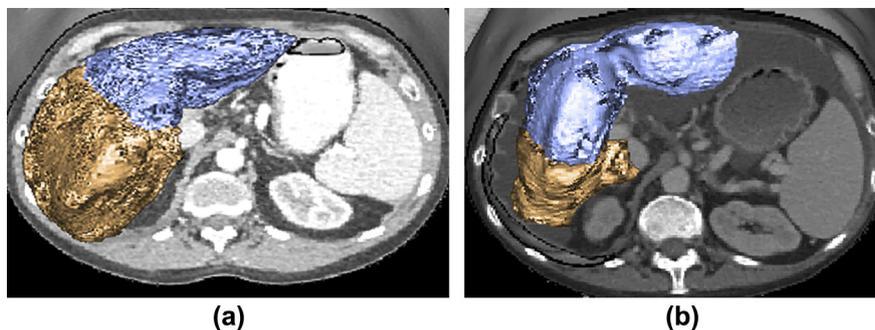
Three-dimensional reconstruction on CT of the liver of a male patient with PSC showing the morphological and volumetric lobar liver changes: (a) at the age of 37 years, with Mayo risk score of 0.65 (<2), MELD score of 10, total liver volume =1782 ml, right lobe (orange) volume =892 ml, left lobe (blue) volume =890 ml, and L/T ratio of 0.50; (b) at the age of 45 years, with Mayo risk score of 4.89 (>2), MELD score of 27, total liver volume =932 ml, right lobe (orange) volume =265 ml, left lobe (blue) volume =666 cc, and L/T ratio of 0.72.
